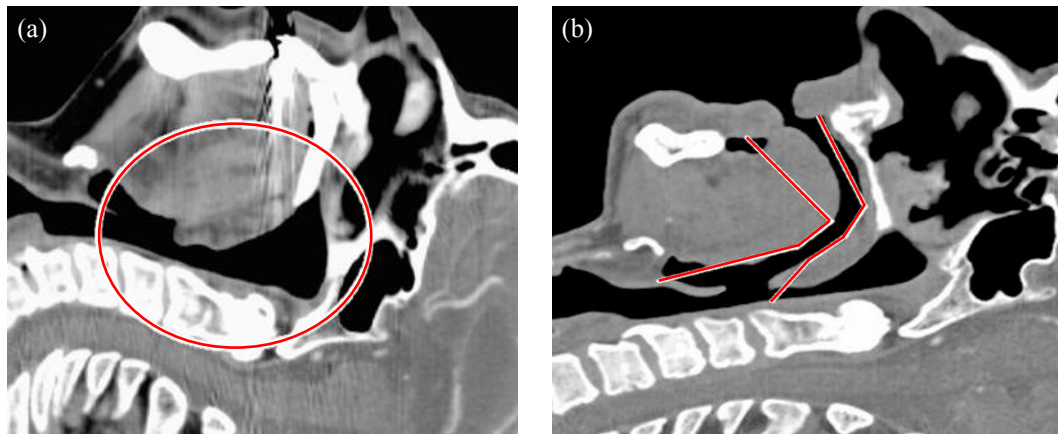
Computed tomography images of upper airway highlighting Venturi tube shape of the pharynx for a (a) nose breather and (b) mouth breather [27].
